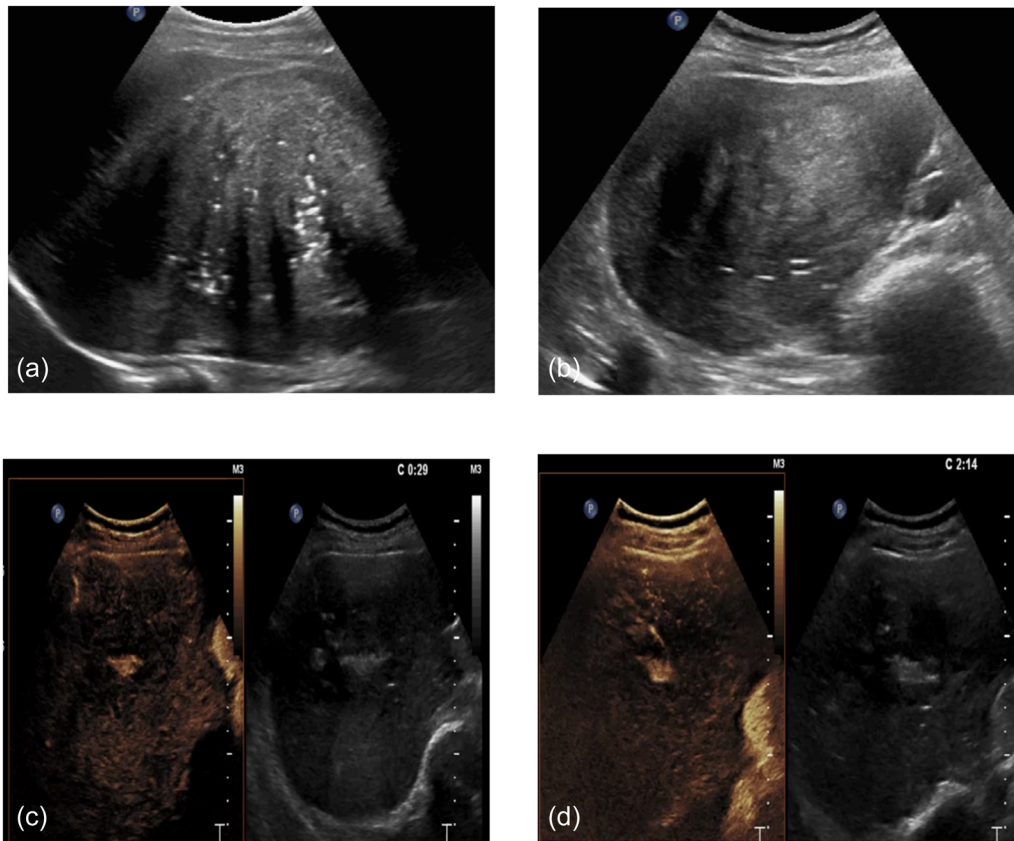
Multimodal ultrasound discovery of the giant mass. (a) B-mode ultrasound longitudinal scan shows a homogeneous and hypoechoic mass with multiple punctate calcifications; (b) the short axis of the transversal scan shows that the mass has well-defined edges; (c) CEUS shows mild and heterogeneous enhancement of the arterial phase; and (d) CEUS continues to enhance during the delayed phase. CEUS, contrast-enhanced ultrasonography.
